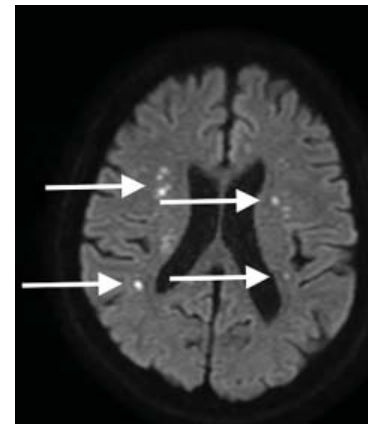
Axial diffusion-weighted magnetic resonance imaging on hospital day 5 showed multiple lesions with high signal intensity in both cerebral hemispheres (arrows).
